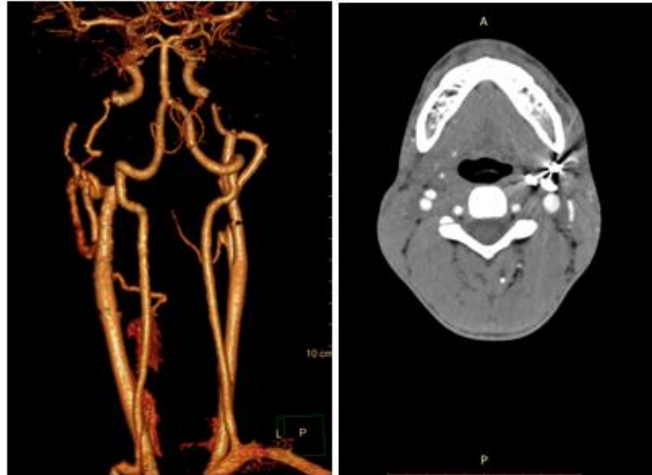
Control Brain CT angiography: totally occluded in bilateral external carotid arteries.
